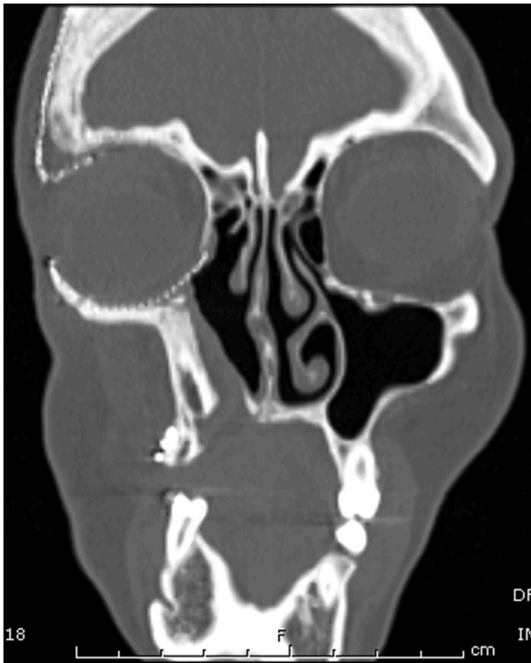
CT finding. The reconstruction included the use of a fibula free flap U-shaped (three bony segments U shaped) and the reconstruction of orbital walls and floor with titanium mesh and bone graft. Rectus abdominis muscle was used to fill the residual maxilla.
